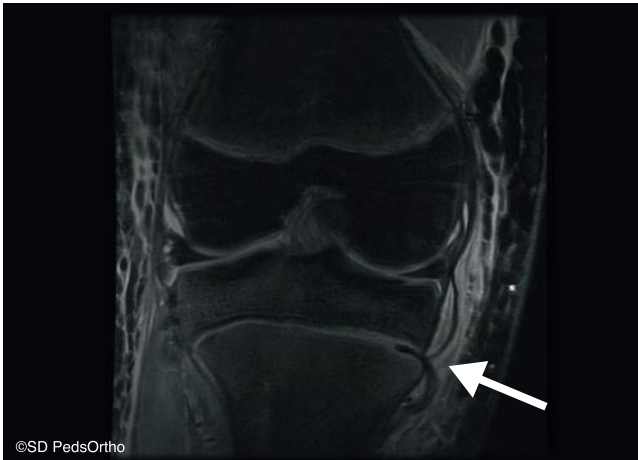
MRI images can assist in differentiating physeal injuries from ligament ruptures. This coronal image demonstrates a proximal tibial physeal fracture with evidence of entrapped medial collateral ligament (MCL) fibers (*arrow*) limiting reduction.
